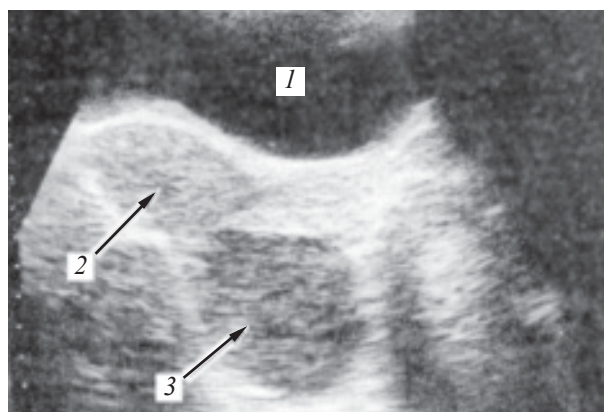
Ultrasonogramm of the patient with an endometrioid cyst of the ovary:
